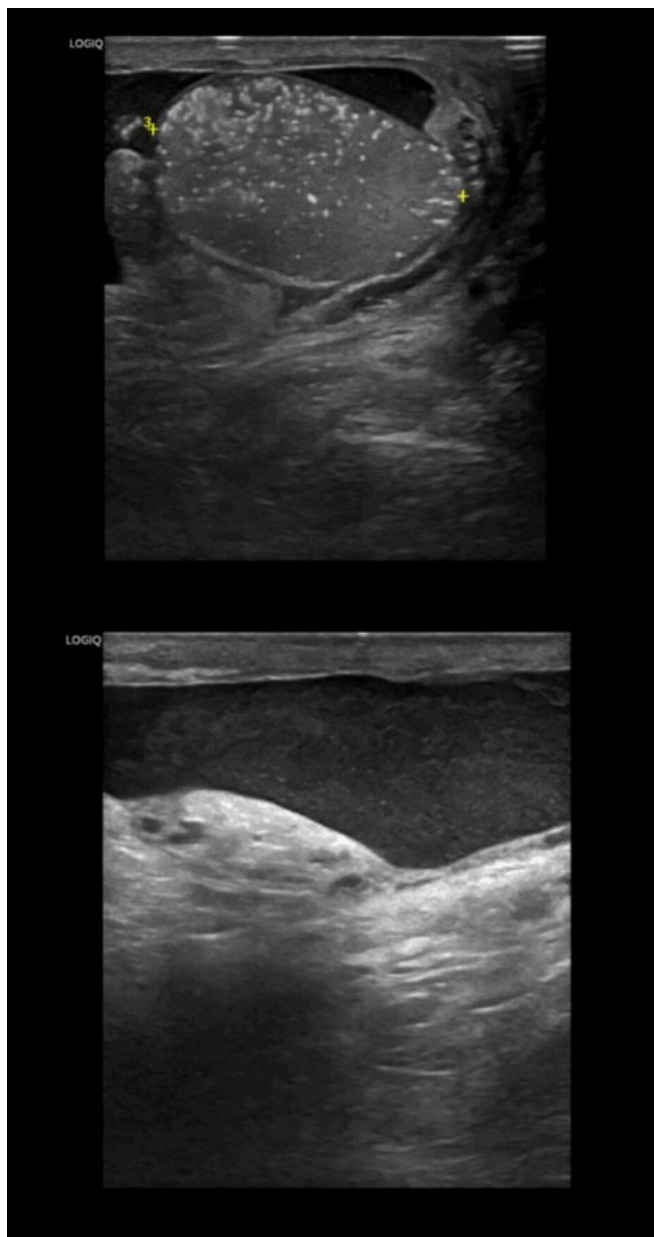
Scrotal ultrasound was compatible with chylocele due to patency of the peritoneo-vaginal canal.
